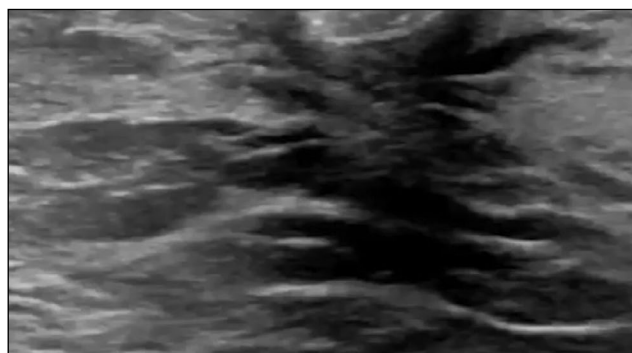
Ultrasound image of the left breast with the inverted nipple.
